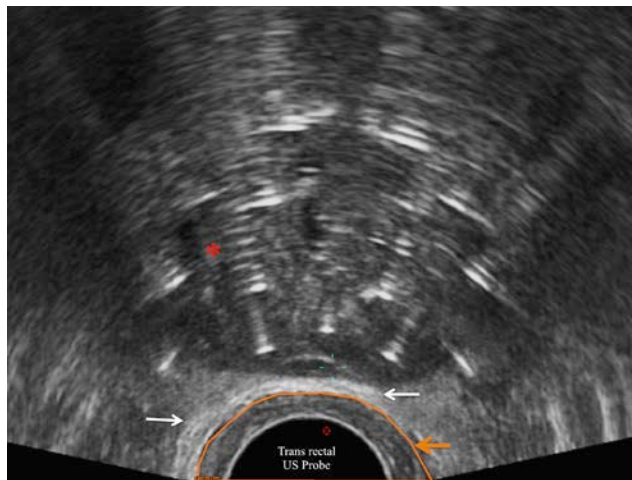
Transrectal ultrasound-based planning. Prostate and catheters inserted (*); the white arrows indicates the posterior layer of Denonvillier's fascia; the orange line and arrow indicates the rectal contour.
